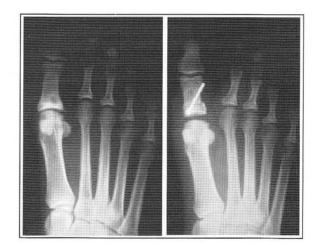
Radiographs of 43-year-old obese white female who presented with a stiff and painful great toe. She had prior bunionectomy with basal osteotomy by an orthopedist. A "autograft" was performed with cheilectomy and excision of the fibular sesamoid. A congruous and painfree joint was re-established as well as excellent correction of the recurrent hallux valgus deformity. Note osteotomy consolidation without resorption or callus.
